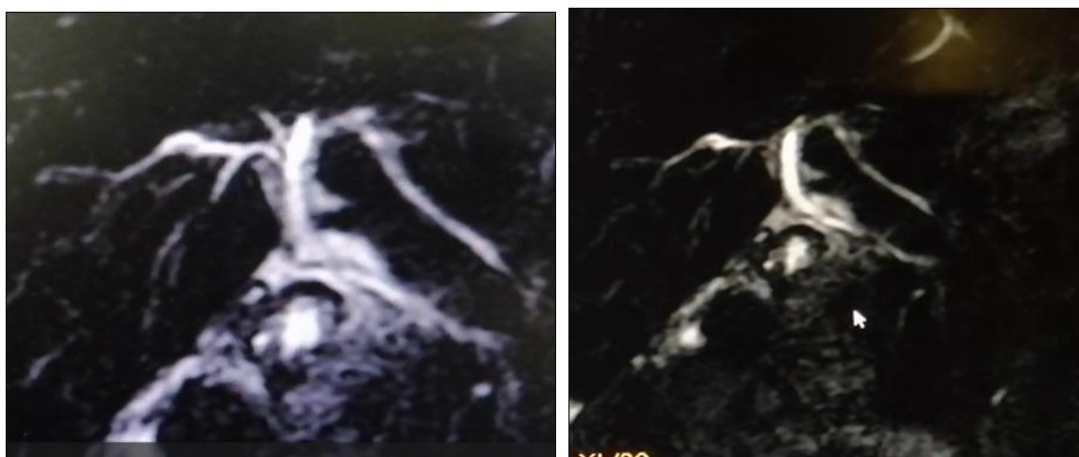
From a cholangio-MRI conclusive to gallbladder agenesis with absence of cystic duct
